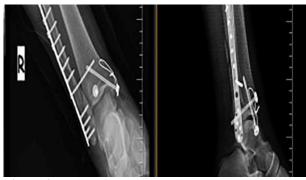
Malleol screw or cortical screw was used as fixation material radiography
